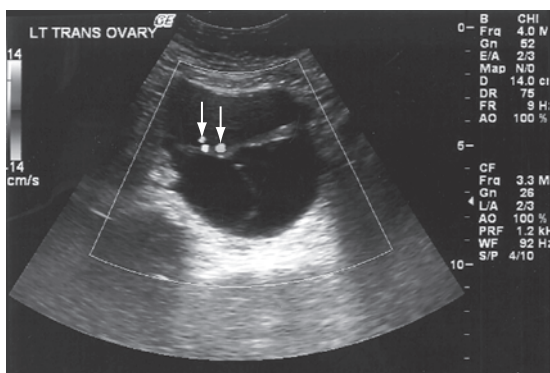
Cystadenocarcinoma. (A) Color Doppler demonstrating internal vascularity (arrows) within a complex mass (see color inserts).
